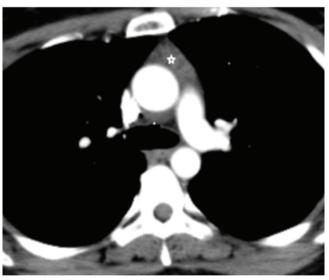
Computed tomography (CT) image of timoma
